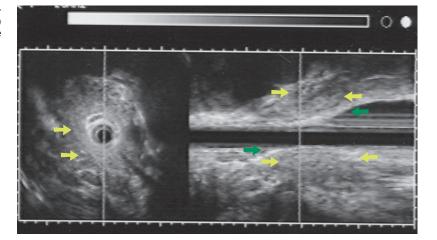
Three-dimensional intraductal ultrasonography showing biliary duct stenosis (*green arrows*) and pancreatic adenocarcinoma (*yellow arrows*).
